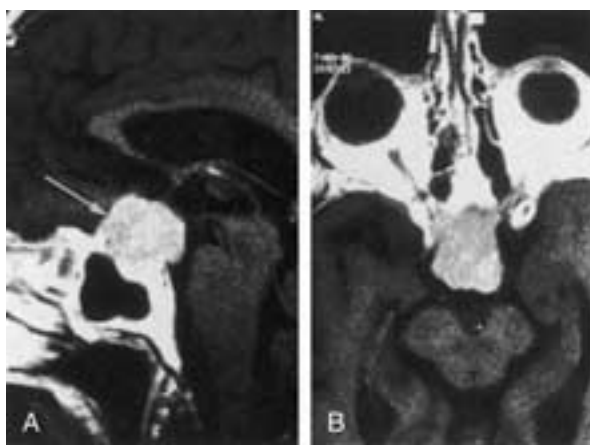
Suprasellar meningioma arising from the planum sphenoidale and diaphragma sellae in a 55-year-old female with bitemporal hemianopsia. A, Sagittal T1-weighted MR image following gadolinium injection shows enhancement of a suprasellar mass (arrows) that compresses the optic chiasm. B, Axial T1-weighted MR image after gadolinium injection shows the anteroposterior and lateral extent of the mass.
